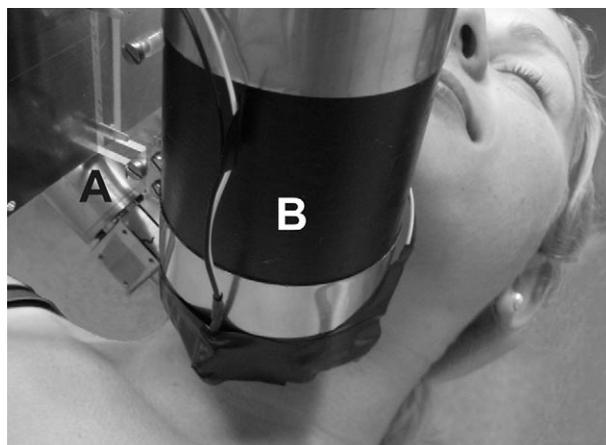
An example of XRF measurement geometry. A basic measurement geometry where an 11.1 GBq ^{241}Am source (A) and an HPGe detector (B) are assembled in fixed positions relative to each other and focused onto a point. Both source and detector are shielded and collimated with lead. The other equipment options may involve multiple sources or an X-ray tube and another detector type.
